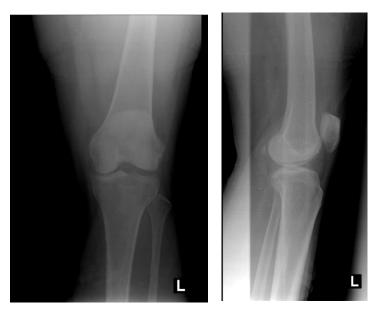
Knee X-ray image shown lateral joint space widening
